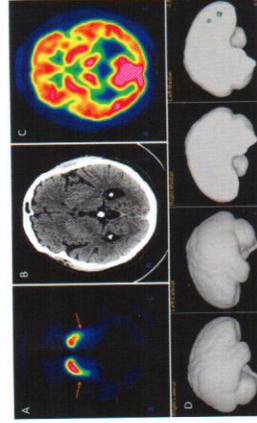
Example of $[^{11}\text{C}]\text{PE2I}$ PET/CT images in a patient with Parkinson's disease with predominantly right-sided clinical symptoms. (A) $[^{11}\text{C}]\text{PE2I}$ images of DAT availability showing asymmetrically reduced uptake in striatum (orange arrows), more pronounced on the left side. (B) CT image at the level of striatum showing no abnormalities. (C) $[^{11}\text{C}]\text{PE2I}$ image of rCBF showing normal perfusion in the cortex and striatum. (D) 3D surface projection map showing perfusion z-scores compared to a healthy control database, indicating perfusion in the normal range in all cortical regions.
